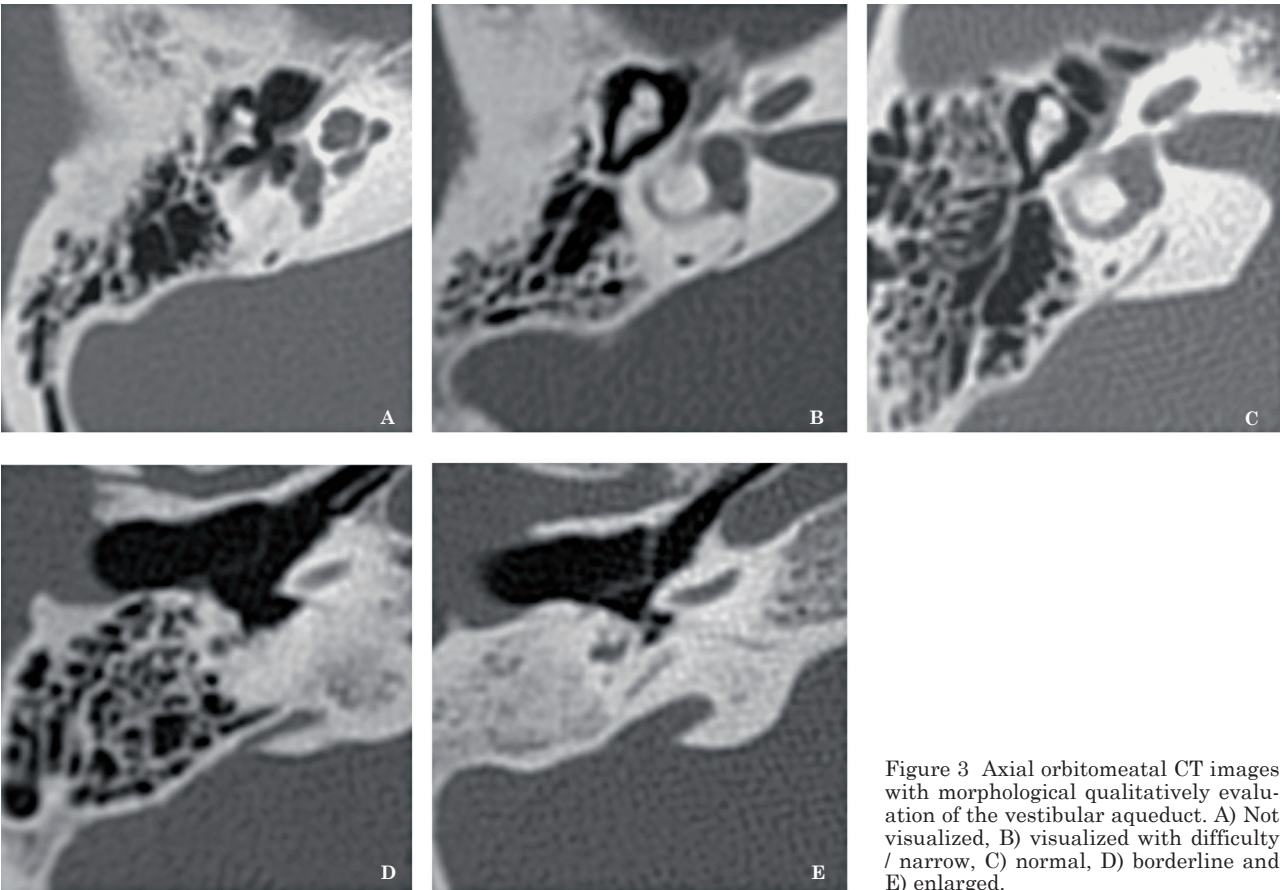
Axial orbitomeatal CT images with morphological qualitative evaluation of the vestibular aqueduct. A) Not visualized, B) visualized with difficulty / narrow, C) normal, D) borderline and E) enlarged.
